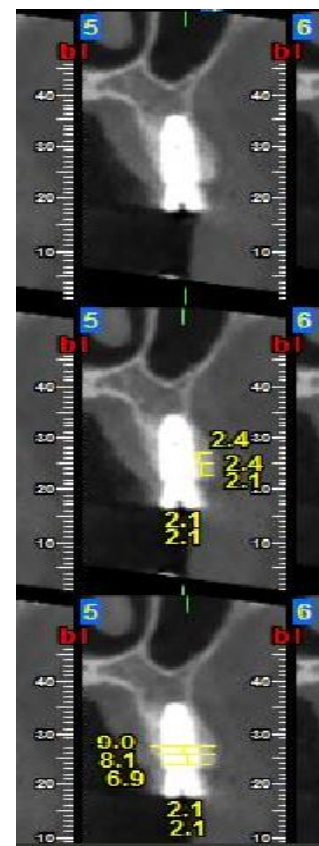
CBCT scans of a representative patient at four months after surgery
